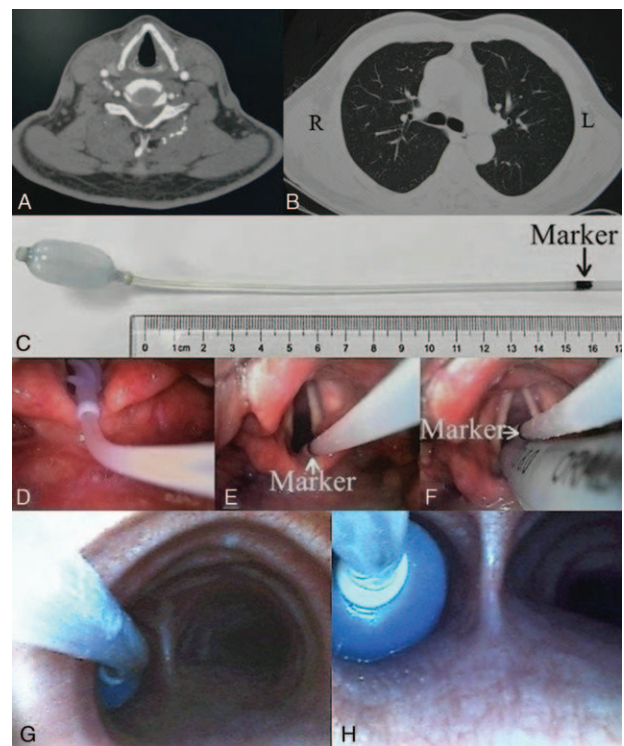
(A) Vocal cord on chest CT image; (B) Carina on chest CT image; (C) Make a marker on the Uniblocker; (D, E, F) Camera view via the video laryngoscope during intubation and the marker on Uniblocker just above the vocal cord; (G, H) The cuff of Uniblocker located below the carina under the view of FOB.
